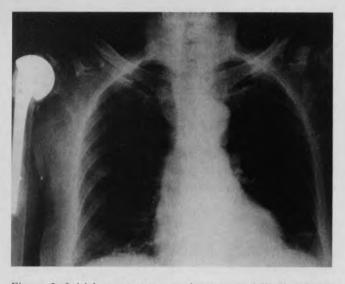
Initial roentgenogram shows essentially clear lungs with normal heart size. Right shoulder prosthesis is also seen.
